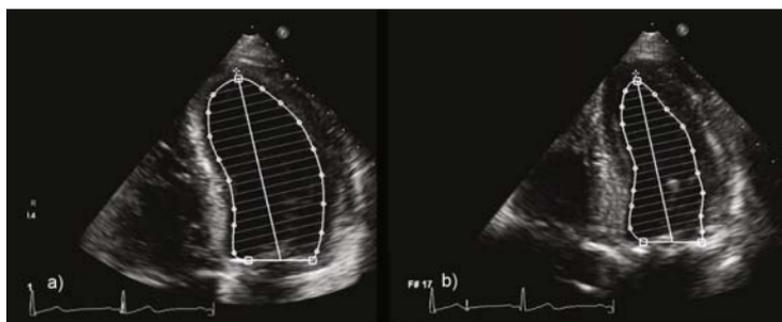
Traced LV cavity area in apical 4-chamber view for volumes and ejection fraction calculations by the echocardiographic machine incorporated software, using Simpson's method. a): end-diastolic frame. b): end-systolic frame.
